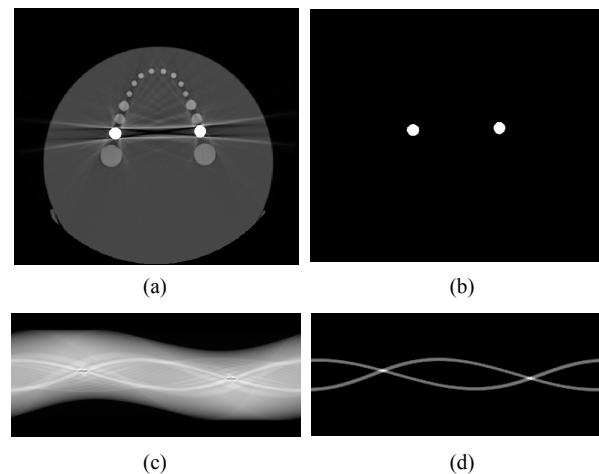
Detection of affected projections: (a) original CT image, (b) metal-only image, (c) original sinogram and (d) metal-only sinogram.
